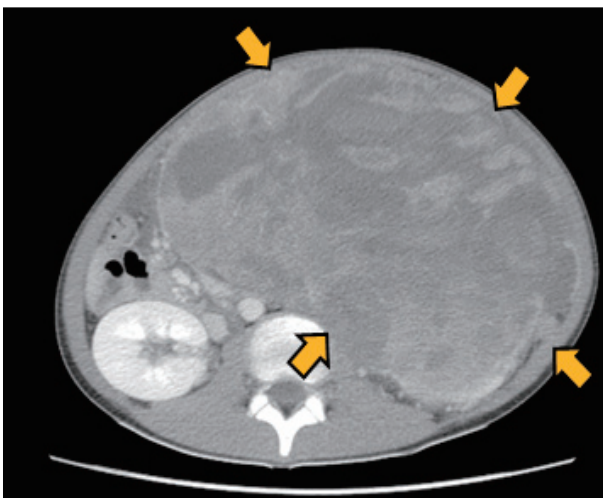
Contrast-enhanced computed tomography (CT) images after the patient developed sudden abdominal pain and hypotension. The tumor was larger than at diagnosis, suggesting intratumoral bleeding. Extravasascular leakage of the contrast agent into the tumor suggested persistent bleeding.
